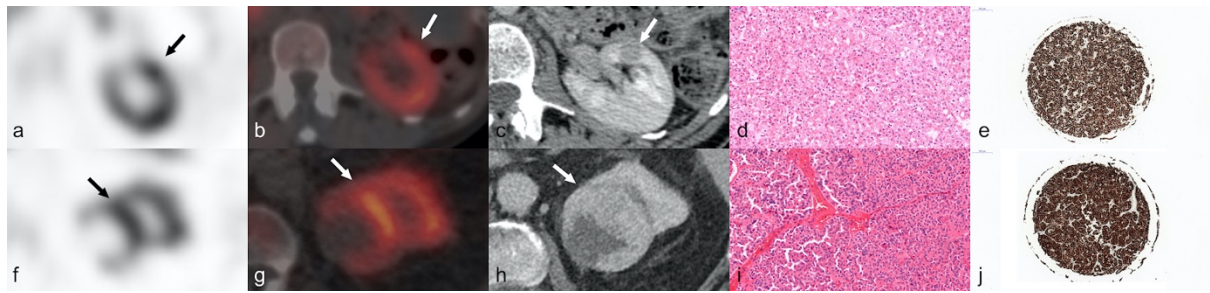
A RO and a HOCT, both positive on ^{99m}Tc-Sestamibi SPECT/CT.
